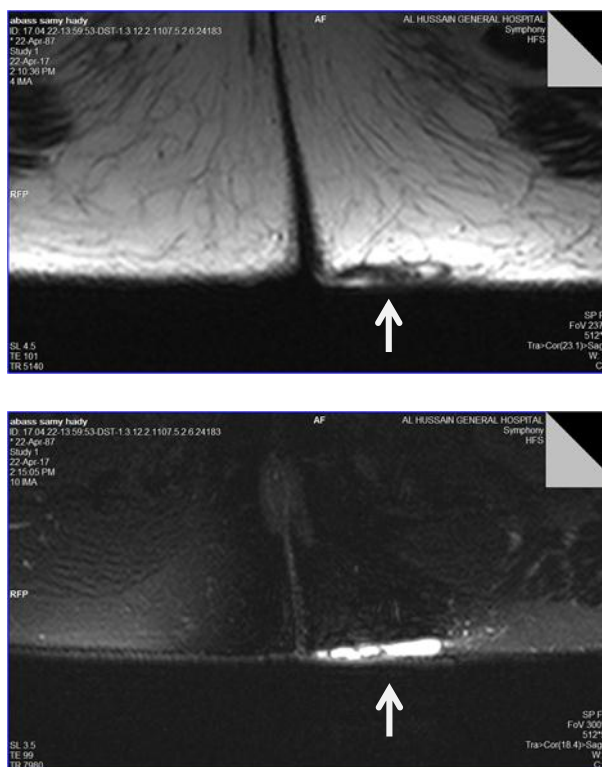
MRI T2w (A) and T2W fat saturation (B) showing the inus (arrow) which proved to be blind end during VAAFT.
